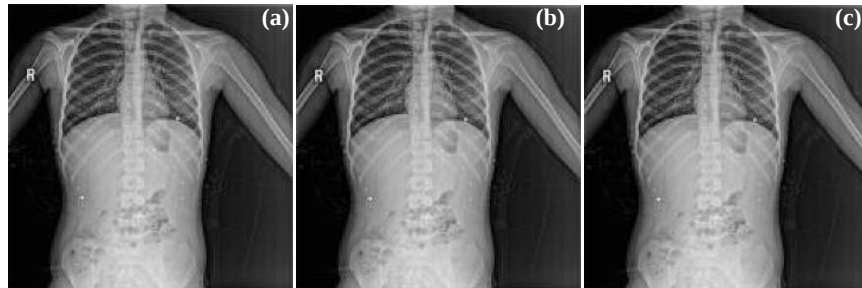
Medical image X-ray encryption using the chaotic method when $X= 1; U = 1$: (a) Original X-Ray Image, (b) Encrypted X-Ray Image, and (c) Decrypted X-Ray Image
